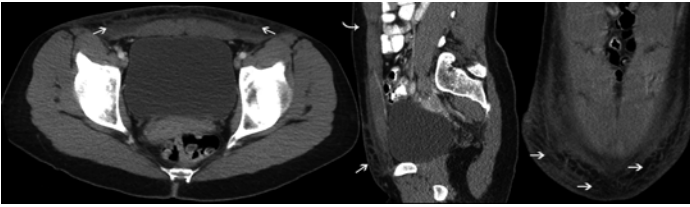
Axial, sagittal, and coronal CT images with features of delayed onset muscle soreness (DOMS), a form of exercise-induced muscular pain that, when involving the abdominal wall or pelvic musculature, may result in groin pain. With severe exertion, rhabdomyolysis and subsequent acute renal failure may occur. The soft tissues and fascial planes of the abdominal wall are diffusely edematous (*white arrows*) as compared to the unaffected tissues (*curved white arrow*) found more superiorly. Findings must be differentiated from fasciitis on the basis of clinical presentation and laboratory results.
